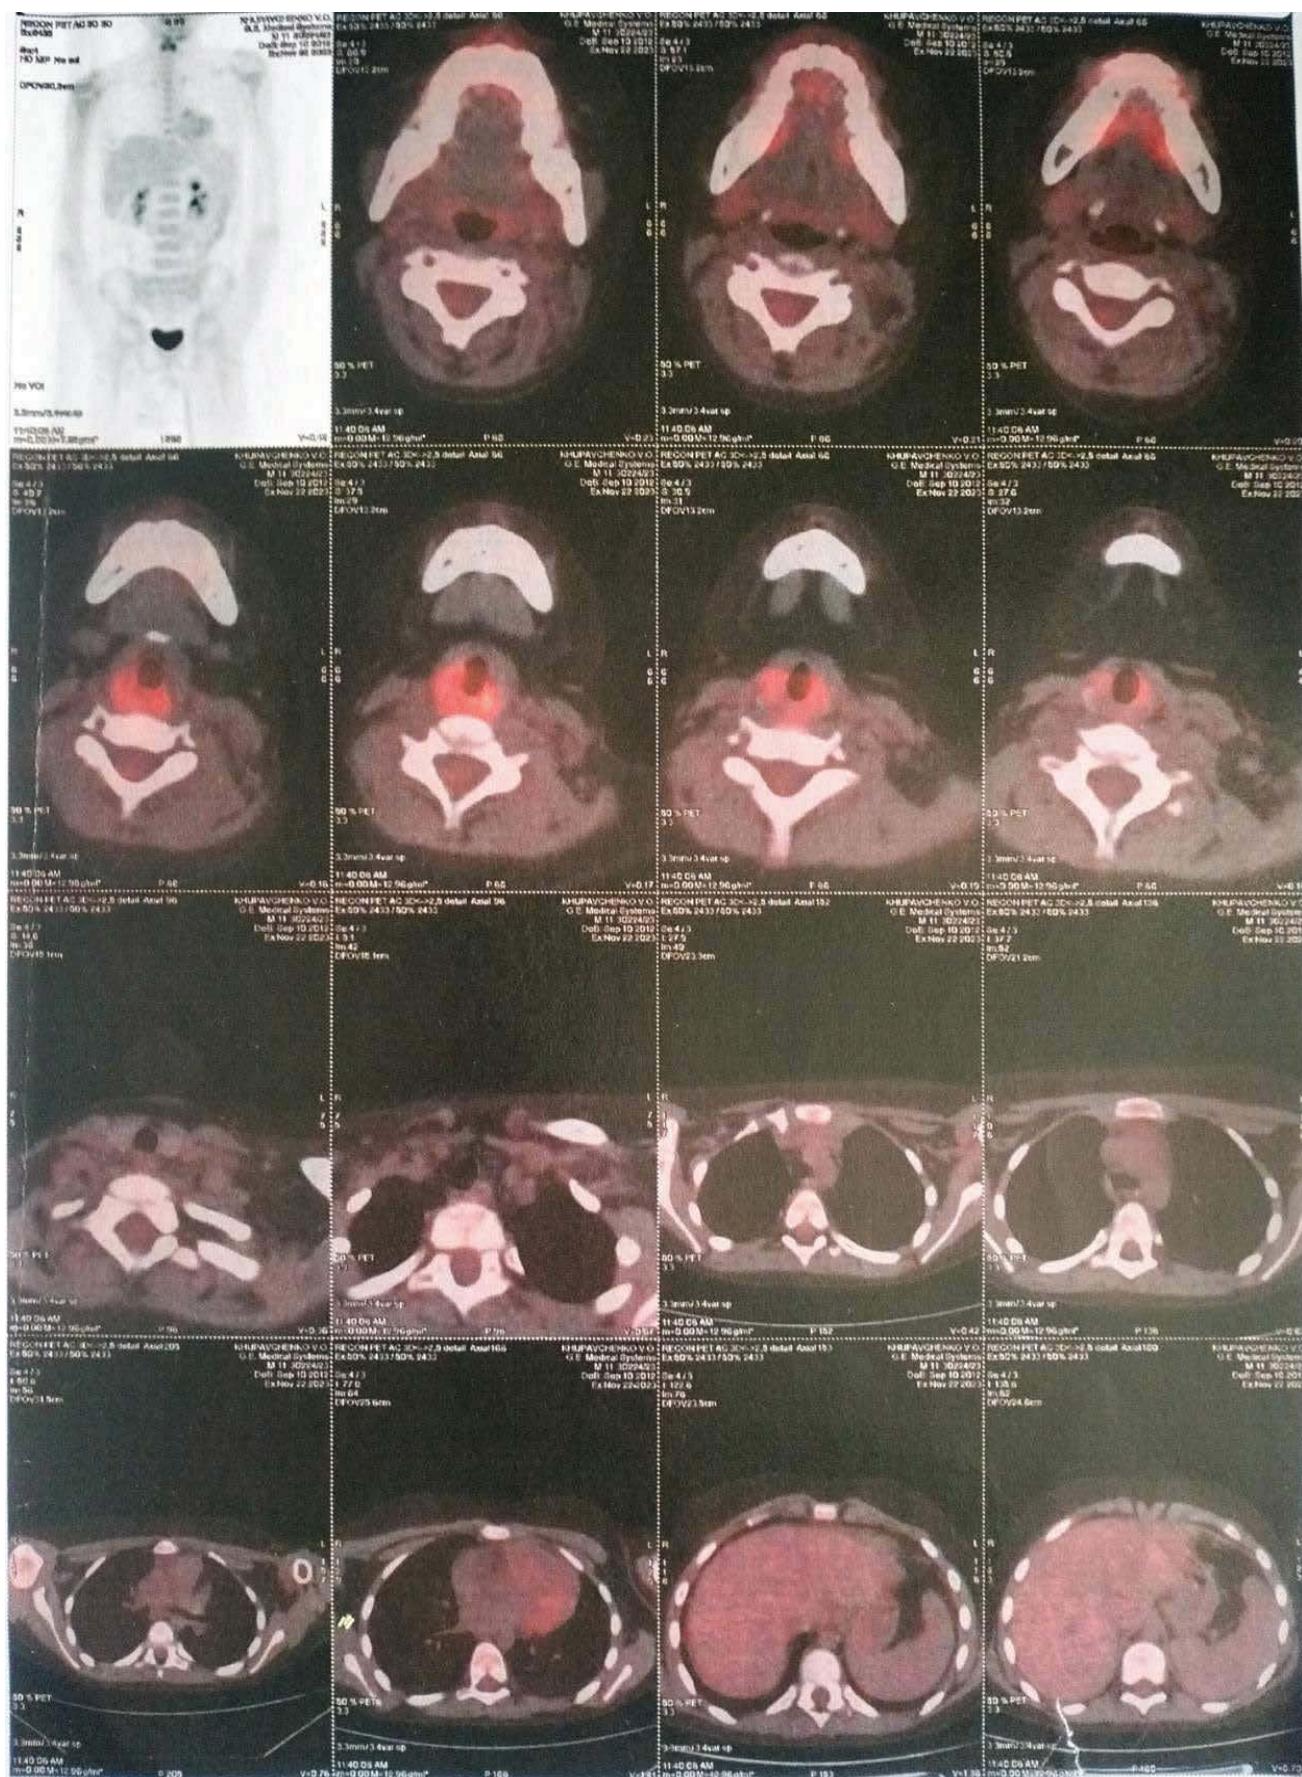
PET-CT scan of a patient after the second block OEPAP
